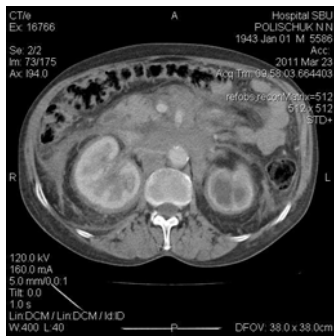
CT of the abdomen with intravenous contrast patient P. Infiltration of cellulose of front pararenal and perirenal spaces with involving great vessels. "Turbid" mesentery. Hydronephrosis of both kidneys. Urolithiasis of the left kidney. Thickened Gerota's fascia (a – parenhimatosis phase, b – ekskretoris phase)
